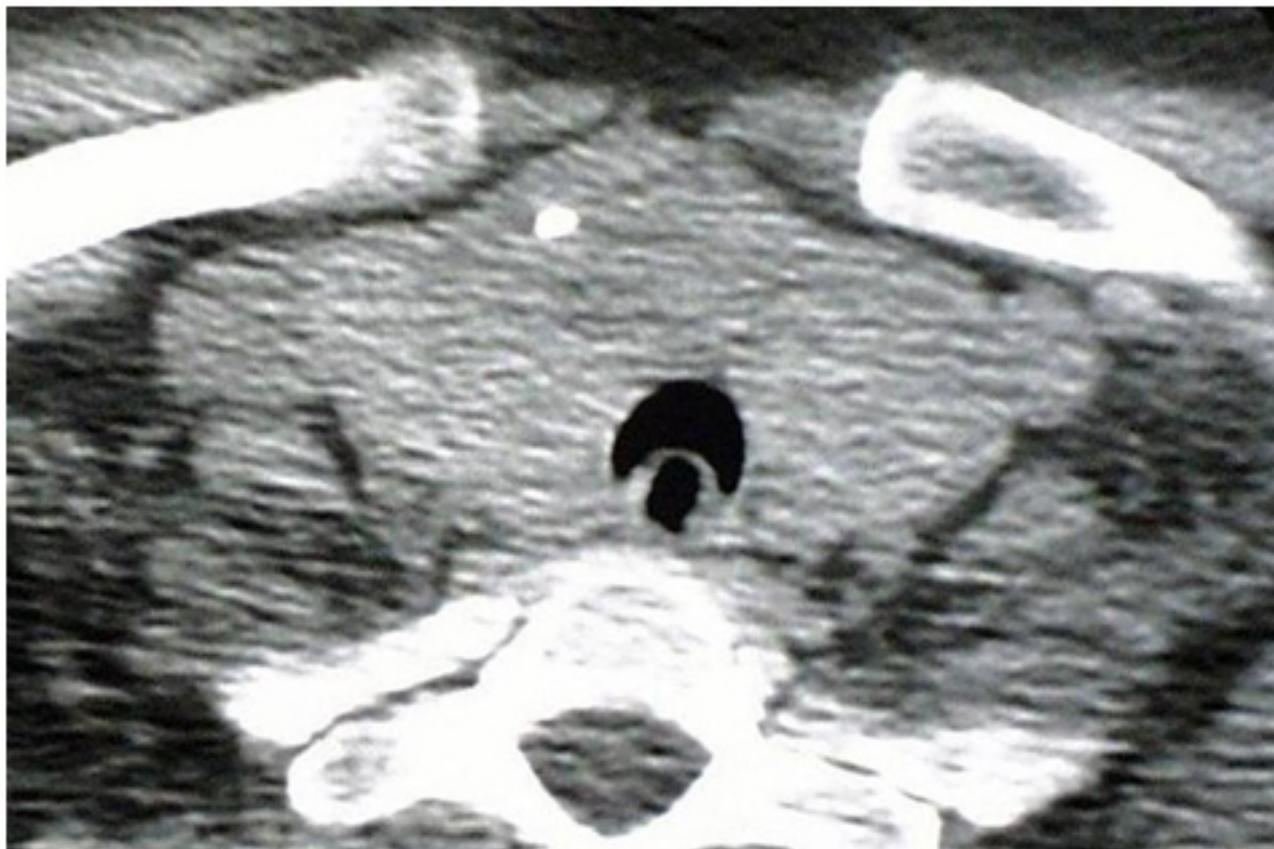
Pre-operative CT scan of the neck demonstrating crescent trachea sign
